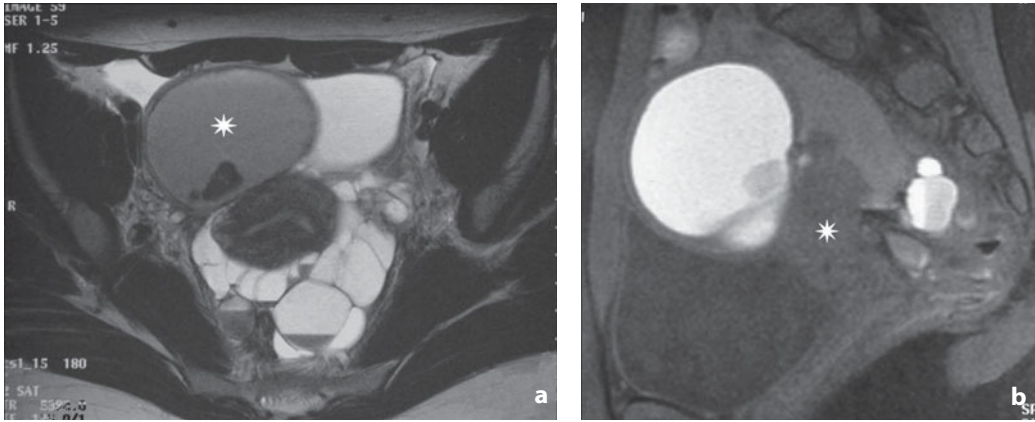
Magnetic resonance. Severe endometriosis. a The rectouterine pouch and vesicouterine space are occupied by multiple cystic formations with varying signal in the T2-weighted image. The largest (*asterisk*) demonstrates the shading effect (progressive signal hypointensity towards the sloping portions) and has thick walls with a clot in the dependent position. b Different case. The rectouterine pouch is occupied by a solid hypointense mass with spiculated margins. Adjacent to it is an endometrioma with thick walls contained in another cystic formation (perforated cyst), (*asterisk*)
